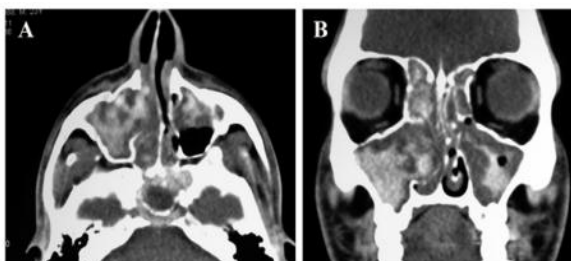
Imaging features of Allergic Fungal Rhinosinusitis (AFRS). (A) Axial CT image of the paranasal sinuses shows heterogeneous hyperattenuating allergic mucin filling the bilateral maxillary sinuses and ethmoid air cells, with areas of mixed density giving a characteristic “double-density” appearance, suggestive of allergic fungal debris. (B) Coronal CT image demonstrates expansile sinus opacification involving the maxillary and ethmoid sinuses with smooth bony remodeling and thinning of the sinus walls, without frank bony destruction.
